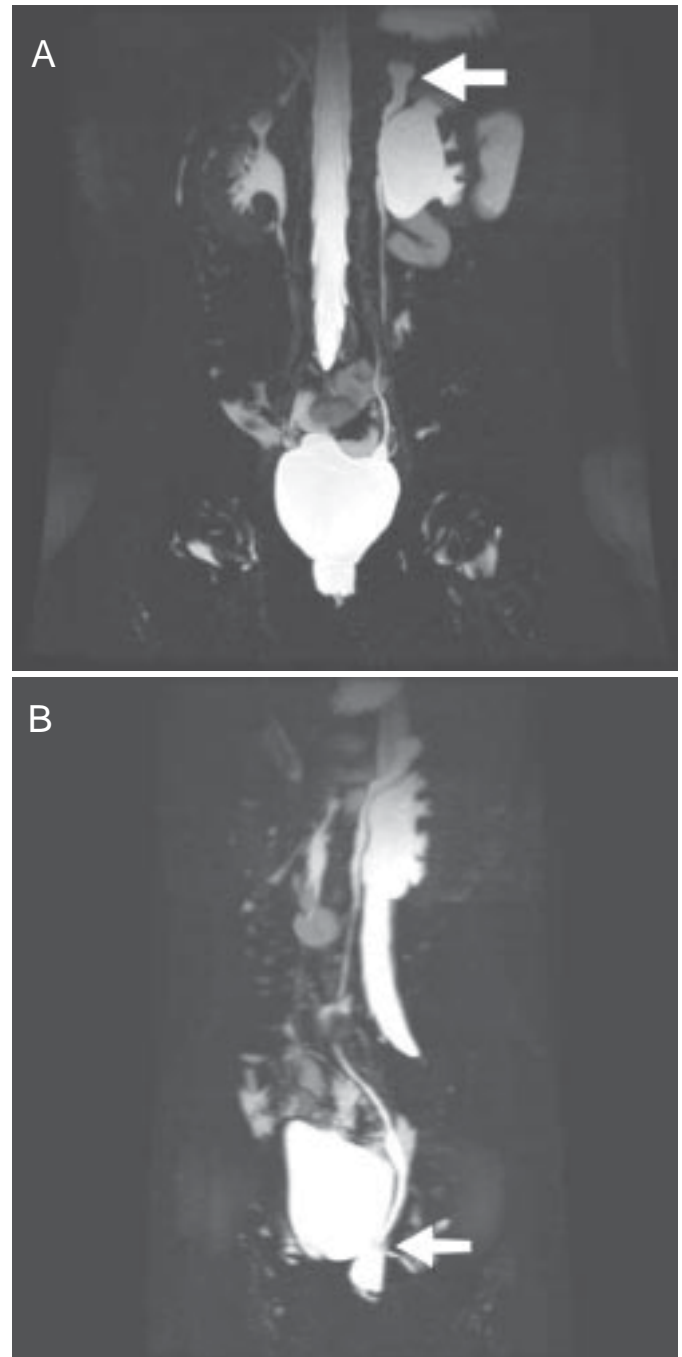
T2-weighted magnetic resonance urography shows. (A) A mildly hypoplastic upper moiety (arrow), lower moiety hydronephrosis and a hydroureter. (B) The upper moiety ureter drains into the vagina (arrow).
